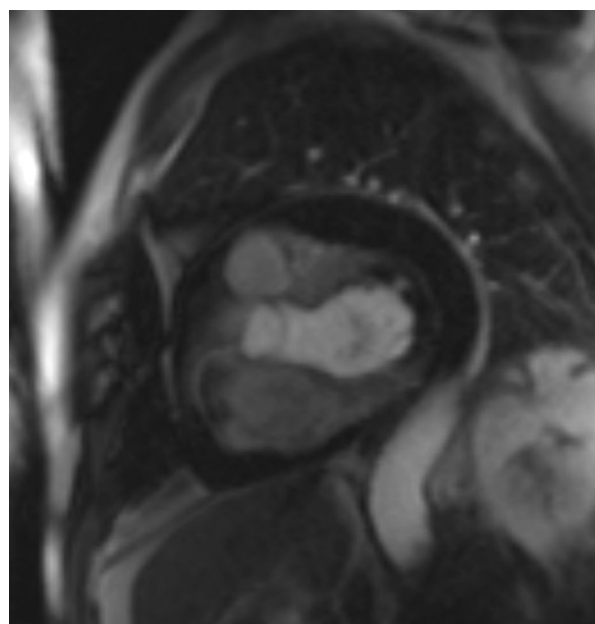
Magnetic resonance imaging with a slit-shaped, incomplete defect in the lateral wall of the left ventricle
